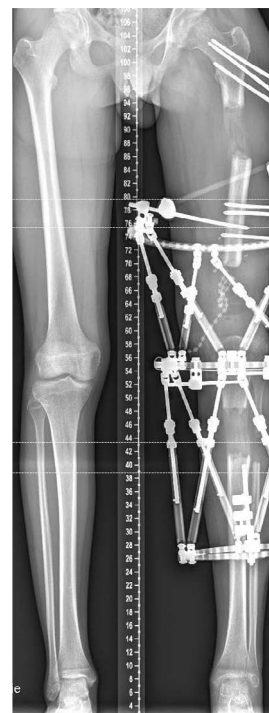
Case 2 – X-ray a.p. views using ring fixation for bifocal callus distraction.
